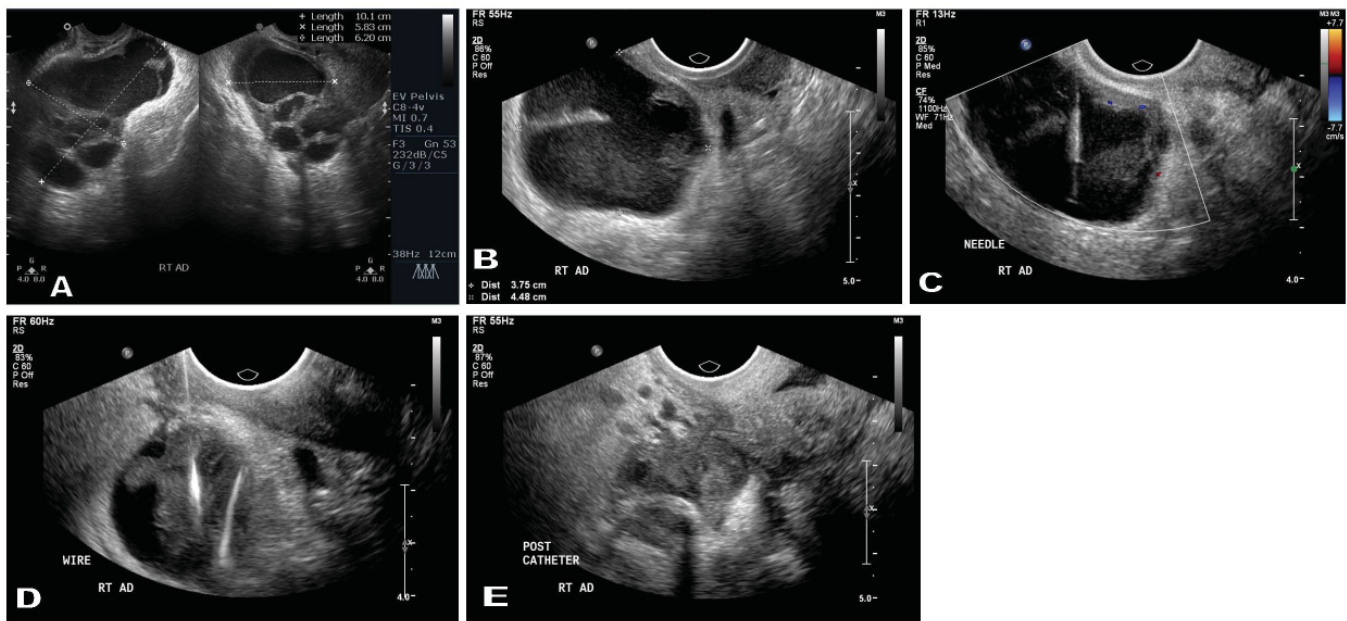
Right tuboovarian abscess in a 29-year-old woman with pelvic inflammatory disease, presenting with fever and lower abdominal pain. (A) Ultrasound pelvis shows a 10.1 x 5.8 x 6.2 cm multiloculated cystic mass in the right adnexa containing internal echoes and prominent vascularity in its internal septations, consistent with a tuboovarian complex. Patient underwent transvaginal ultrasound guided drainage 2 days after initial ultrasound. (B,C,D) The transvaginal probe, equipped with a needle adapter, was inserted into the vagina. Under direct ultrasound guidance, a 18G needle was advanced into the right adnexal cystic lesion via the needle adapter. A 0.035 guidewire was then advanced into the collection. (D) A 8F drainage catheter was then inserted over the guidewire with pigtail deployed into the collection. The catheter was then connected to a vacuum drainage bottle and secured with adhesive dressing to the thigh. (E) A post-drainage ultrasound image with the catheter in situ.
